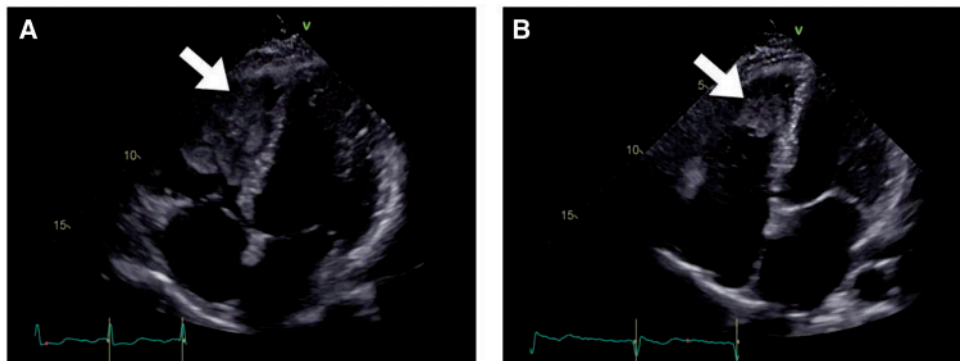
Transthoracic echocardiography before and after treatment. There is a large space-occupying mass in the right ventricle with adhesion on the apex and septum (white arrow) with a maximum expansion of 4.0 cm × 4.5 cm × 5.5 cm before chemotherapy (A). The lesion declined considerably under treatment (B) with a residual expansion of 3.3 cm × 3.0 cm (white arrow).
